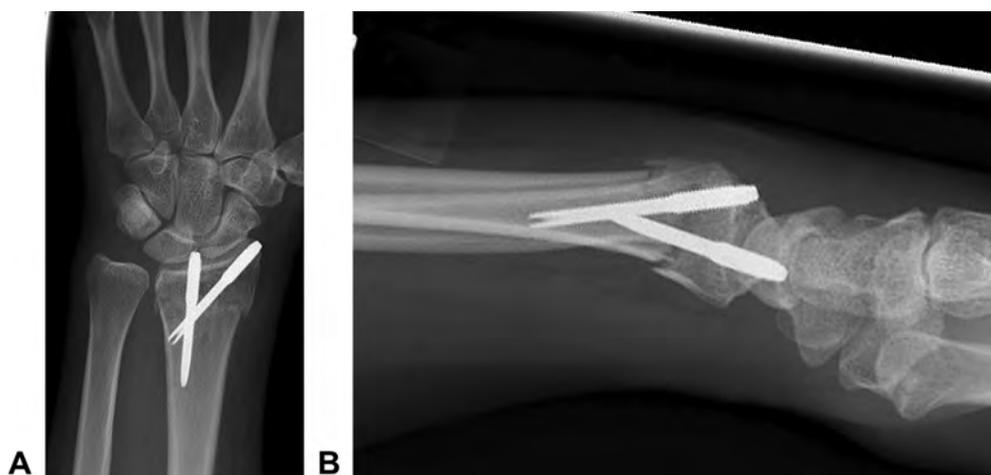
A Anteroposterior postoperative radiograph of distal radius fracture and B lateral radiograph of distal radius fracture.
